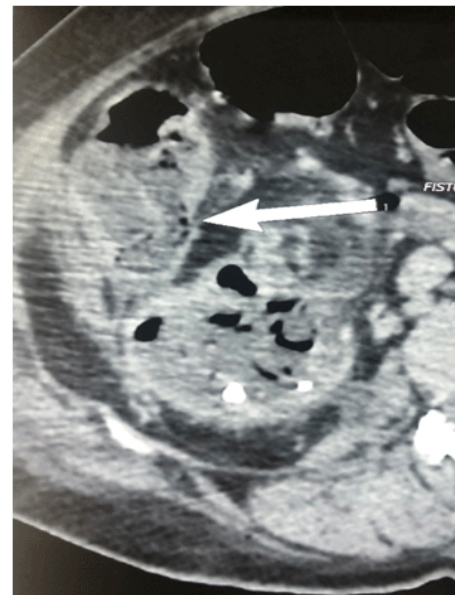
Sagittal CT scan section showing renocolic fistula
